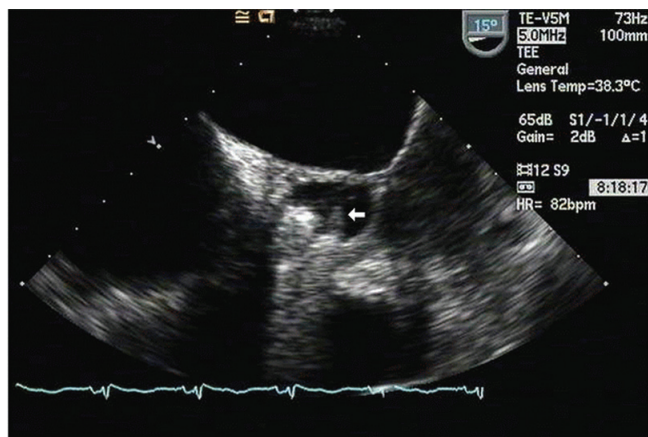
Trans-esophageal echocardiographic image of prosthetic aortic valve vegetations. White arrow indicates largest fungal vegetation identified in this case.
